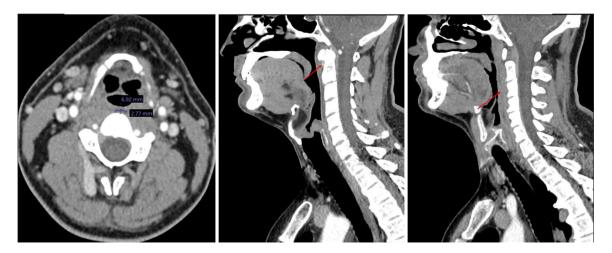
CT imaging demonstrating internal improvement of the fluid filled retropharyngeal space (left), calcific deposition of the longus coli tendon (middle) and edema of the longus coli muscle after symptomatic treatment with NSAIDs and steroids.
